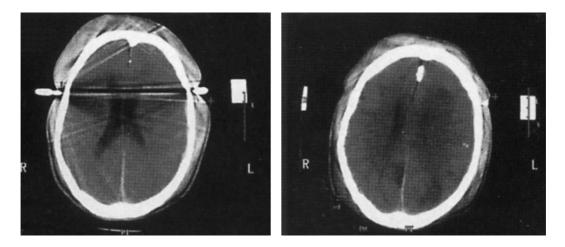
Head CT scan obtained approximately 6 h later. The previously observed left-sided acute SDH has been significantly decreased in size and the effacement of the ipsilateral ventricle and the midline shift had also been improved.
